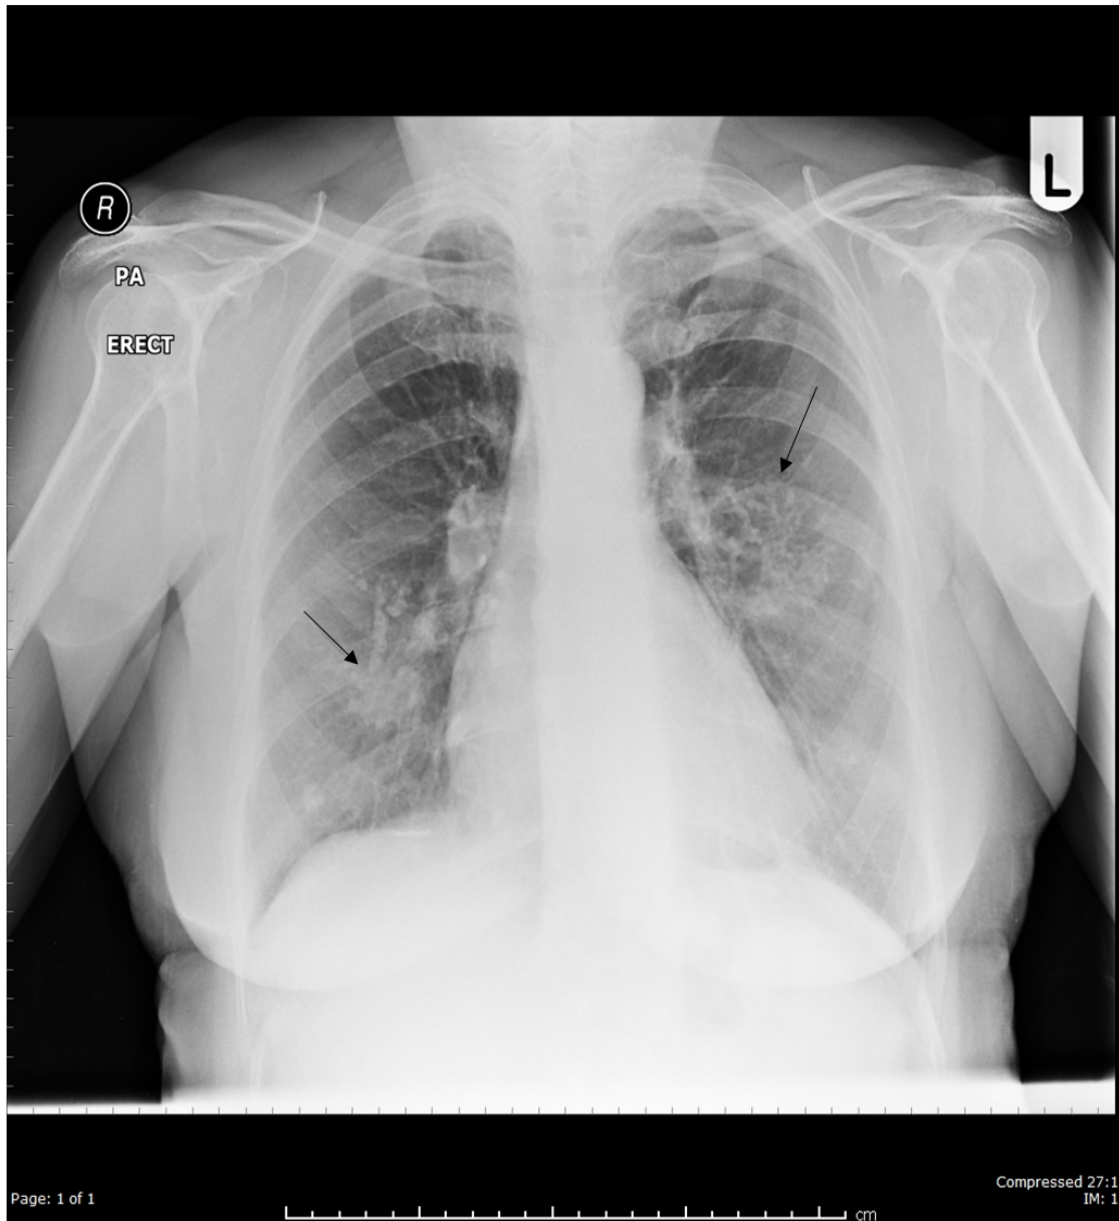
Pleural plaques (shown in black arrows) as seen on chest radiograph
